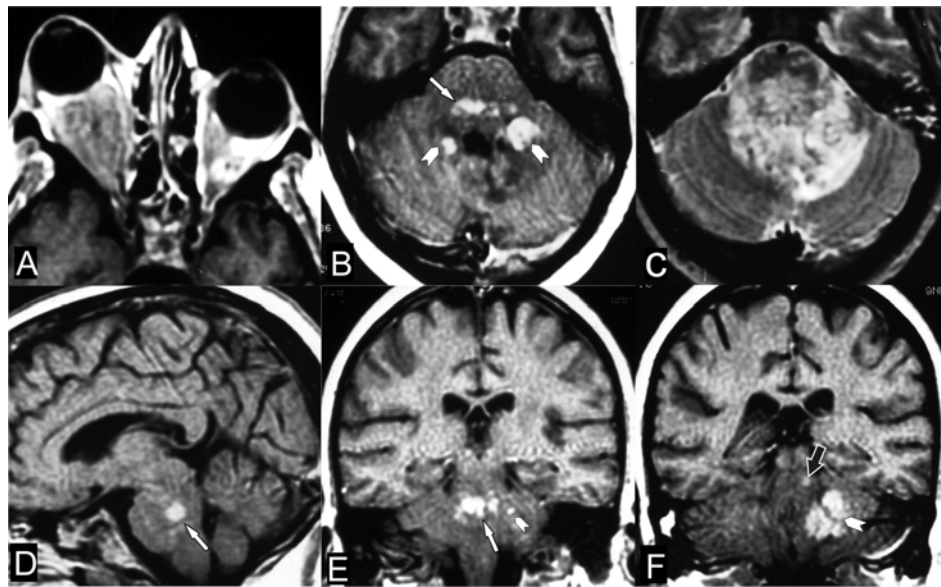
Post-contrast axial T1-weighted magnetic resonance imaging (MRI) demonstrates enhancing (A) right orbital, retrobulbar massive infiltration with prominent exophthalmos and recurrence of the left retrobulbar mass, as well as (B) nodular enhancing lesions in the pontine tegmentum (white arrow) and the middle cerebellar peduncles (white arrowheads) with perifocal edema. Axial T2-weighted MRI (C) shows bright asymmetric hyperintense signal in the pontine tegmentum and the middle cerebellar peduncles predominantly on the left side. Post-contrast sagittal (D) and coronal (E, F) T1-weighted MRI demonstrates nodular enhancing lesions in the pontine tegmentum (white arrows), left middle cerebellar peduncle (white arrowheads) and ipsilateral midbrain tegmentum (black arrow).
